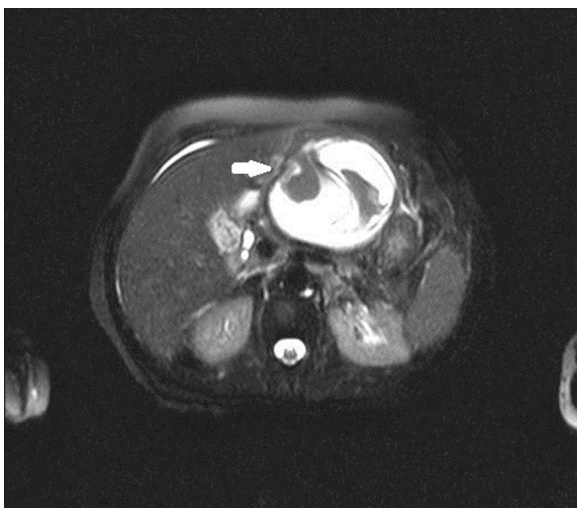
MRI image showing the drained cyst consisting blood in left lobe of liver, magnetic resonance cholangiopancreatography.
